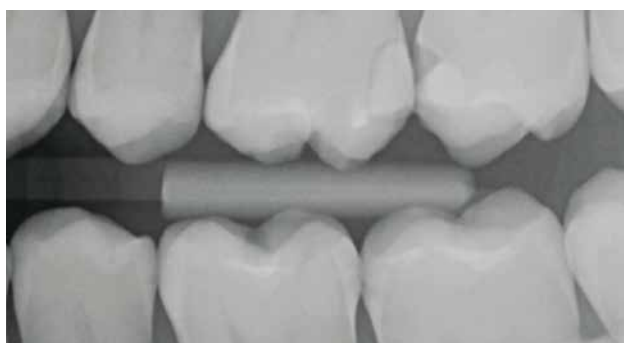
The X-ray image confirmed the clinical findings in the second quadrant. With both tooth 37 mesial and tooth 36 distal approximal caries (C2) can be seen.
